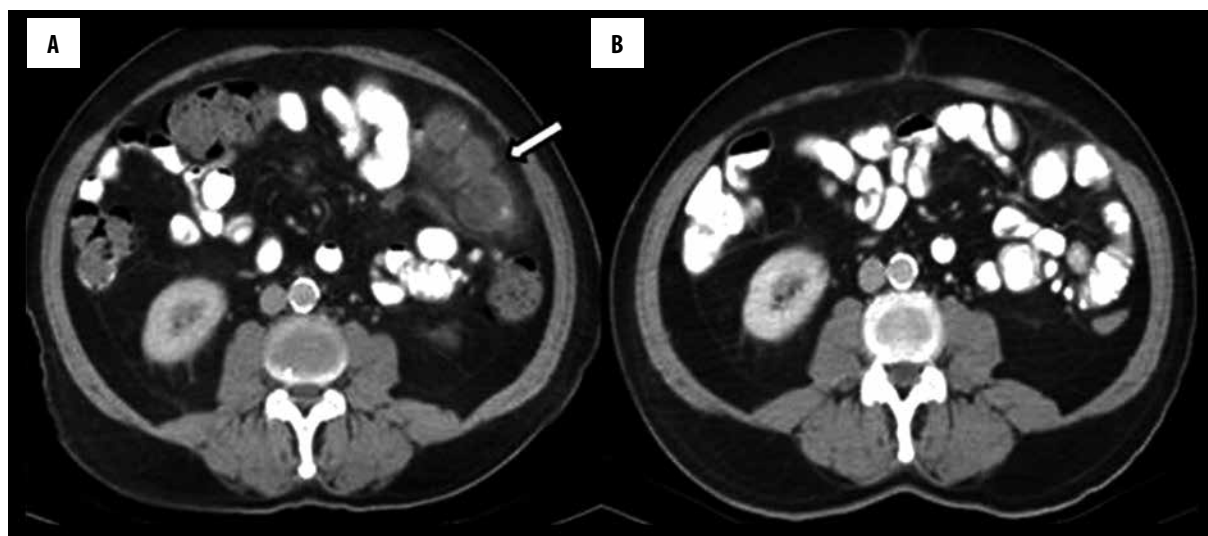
Contrast-enhanced abdominal CT, with oral contrast medium: axial images; (A) A segment of the jejunum with three diverticula is observed, with wall thickening and increased density of the surrounding mesenteric fat tissue (arrow); (B) Control CT axial image 4 weeks after healing at the same level of the abdomen showed that diverticulitis findings were regressed.
